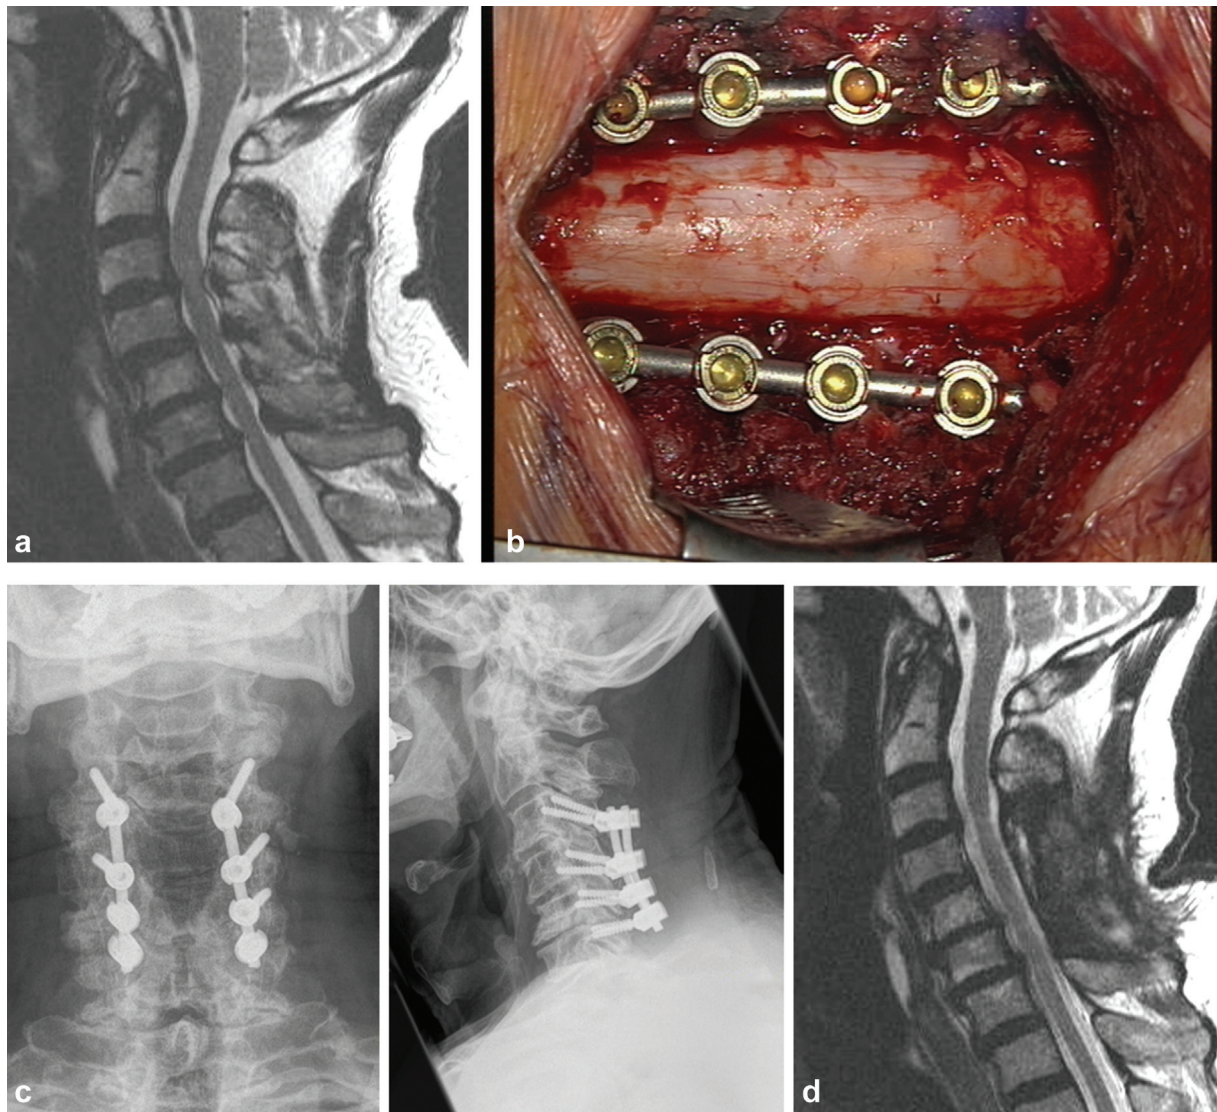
Clinical case of a laminectomy with bilateral stabilization in a 67-year-old female patient with multisegmental degenerative cervical myelopathy. The preoperative modified Japanese Orthopaedic Association (mJOA) score was 10/17 and the postoperative mJOA score was 14/17. (a) Preoperative sagittal T2 magnetic resonance imaging (MRI). (b) Intraoperative situs. (c) Postoperative anteroposterior (*left*) and sagittal (*right*) X-rays. (d) Postoperative sagittal T2 MRI.
